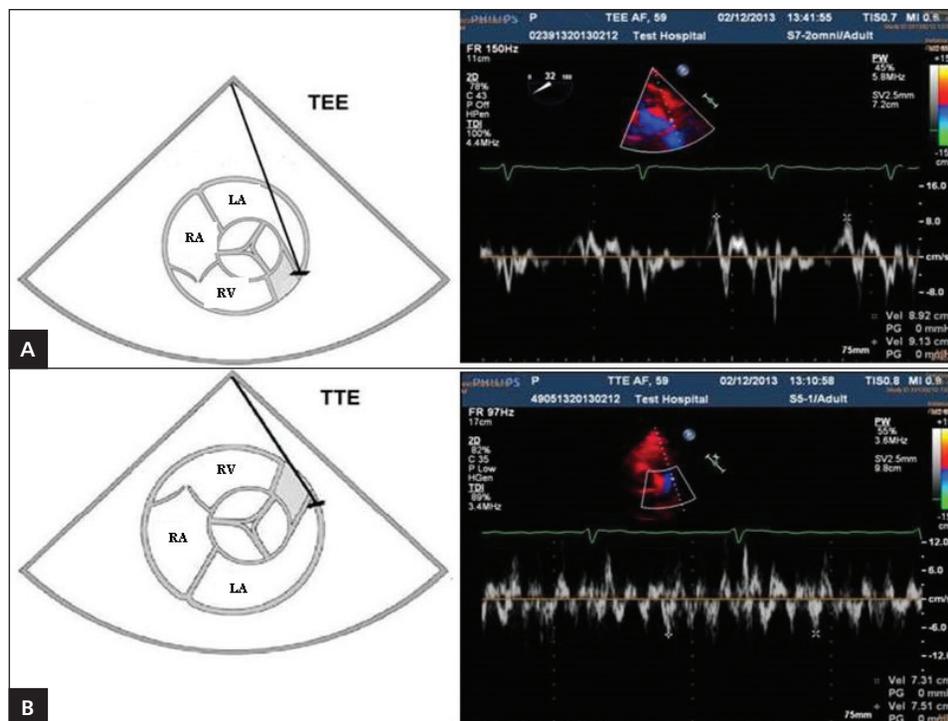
Left atrial appendage apex movement detection by spectral tissue Doppler imaging by transthoracic echocardiography — TEE (A) and transoesophageal echocardiography — TEE (B); LA — left atrium; RA — right atrium; RV — right ventricle
